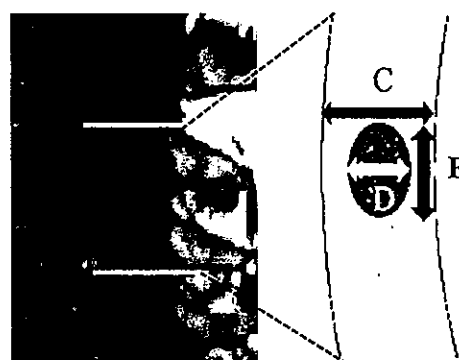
T1-weighted image. Black arrow (C) cervical spinal cord antero-posterior diameter. White arrow (D) T1-low antero-posterior diameter. T1-low diameter ratio was D/C(%). Gray arrow (E) T1-low cranio-caudal diameter (mm).
